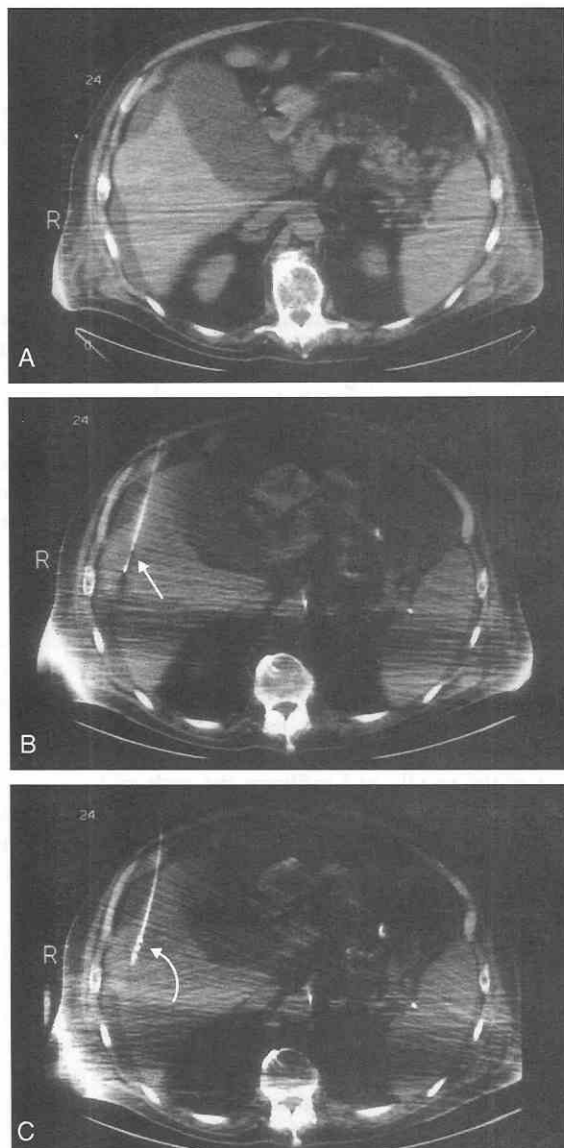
A, CT scan shows a mass in the lateral portion of the right lobe of the liver. B, Cannula with cutting needle is located in the liver; arrow points to gap. C, Scan shows the coil at the end of the cannula being inserted into the liver.
